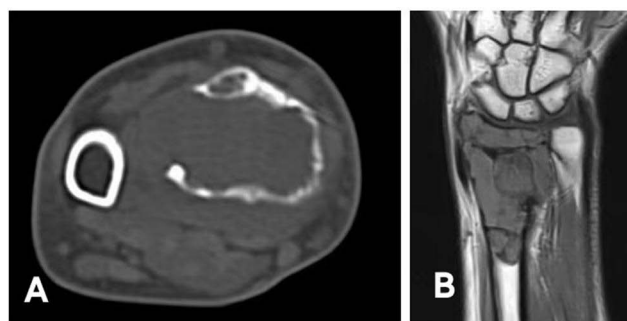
(A) A CT image and (B) a MR image of patient 22 show cortical destruction and soft tissue extension of the GCT.
